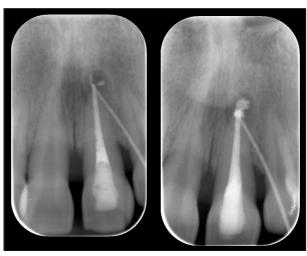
Radiograph (fistelogram) of 21 before retreatment 20.10.2011
